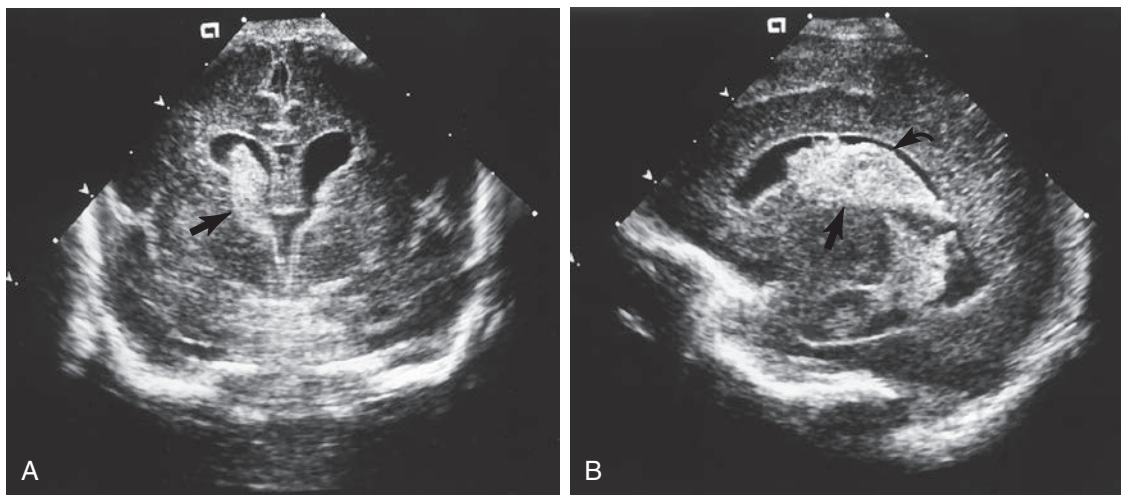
Coronal (A) and parasagittal (B) ultrasound images from a cranial ultrasound study demonstrate an echogenic clot (arrows) within the dilated right ventricle. The intraventricular clot with ventricular dilation defines a grade III hemorrhage.
